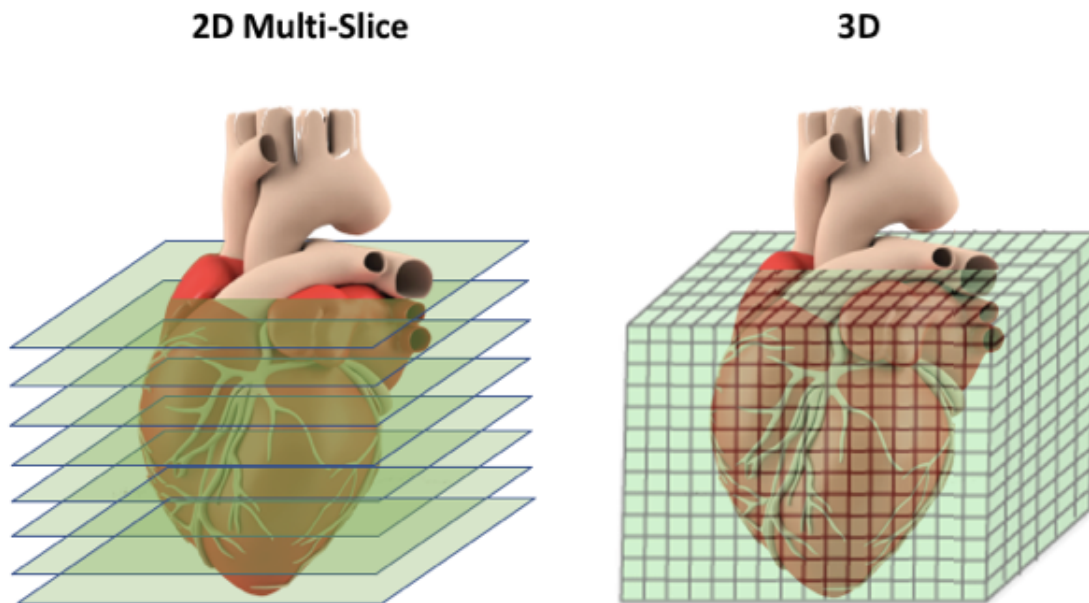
2D versus 3D LGE-MRI for imaging the full-heart. 2D MR image model on the left uses only 8 slices from consecutive locations of the heart. On the right, the high-resolution 3D LGE-MRI represents the heart as a volume using many slices. In a real LGE-MR image, 3D will have more slices than it appears on the image.
